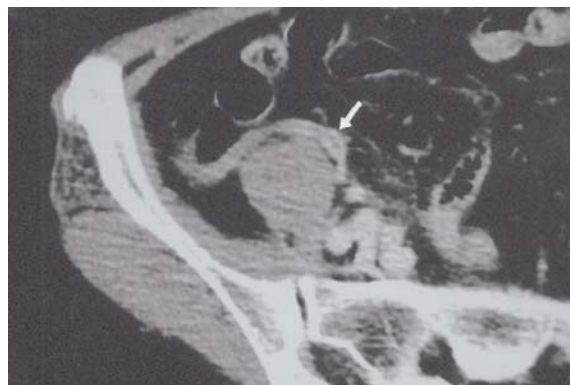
Enhanced axial CT image shows enhancement of the body and tip of the appendix (arrow).
